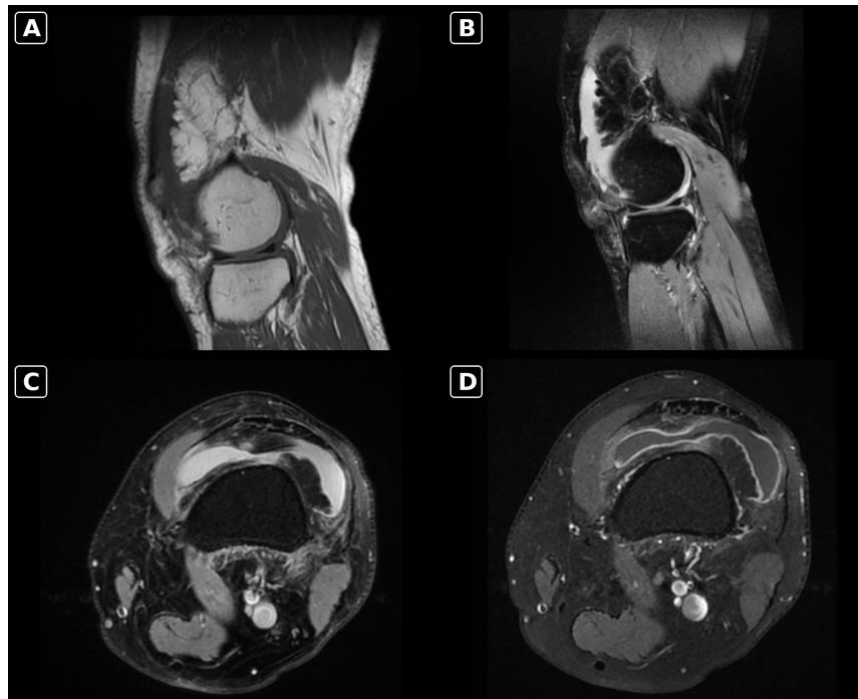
MRI appearance of lipoma arborescens. (A) Sagittal T1-weighted image shows frond-like hyperintense synovial projections in the suprapatellar recess, following the signal intensity of subcutaneous fat. (B) Sagittal and (C) axial PD-FS images demonstrate suppression of the fatty villi, which are outlined by a moderate joint effusion. (D) Axial post-gadolinium T1-weighted fat-suppressed image shows non-enhancement of the fatty villous cores with enhancement of the synovial lining.
